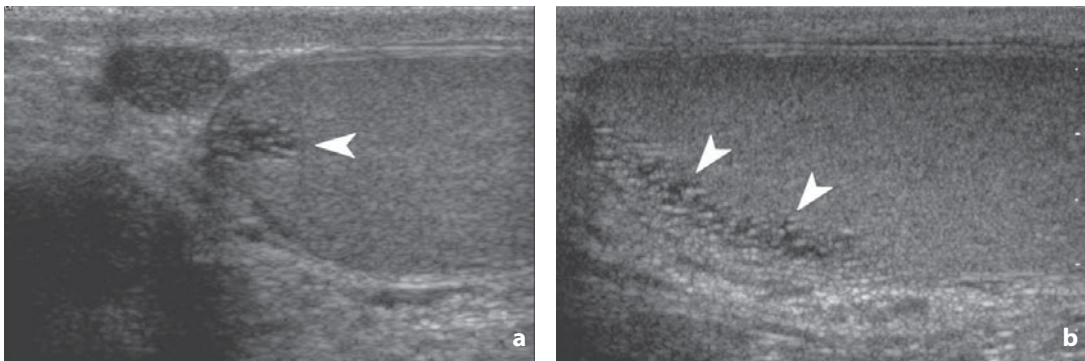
Cystic ectasia of the rete testis. Axial (a) and sagittal (b) sonograms. The alteration (*arrowheads*) situated at the mediastinum testis appears as a collection of small liquid formations with a tubular appearance and separated by thin septations
